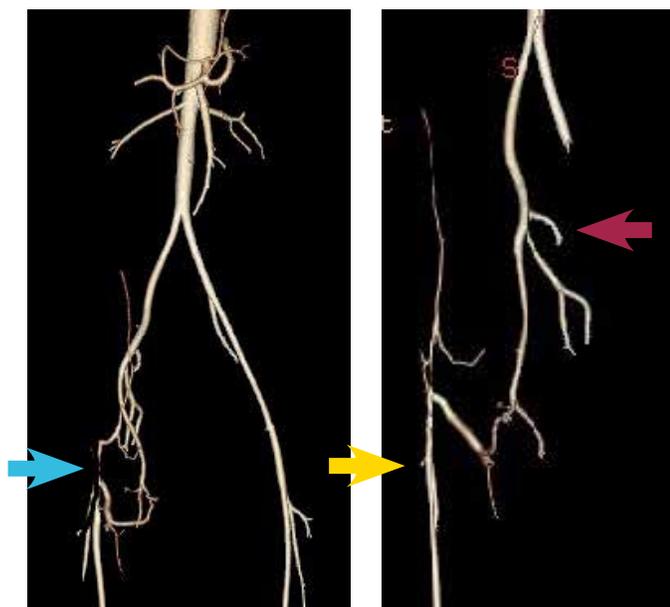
CT angiogram with 3-D reconstruction; note the occluded right external iliac artery (blue arrow).
